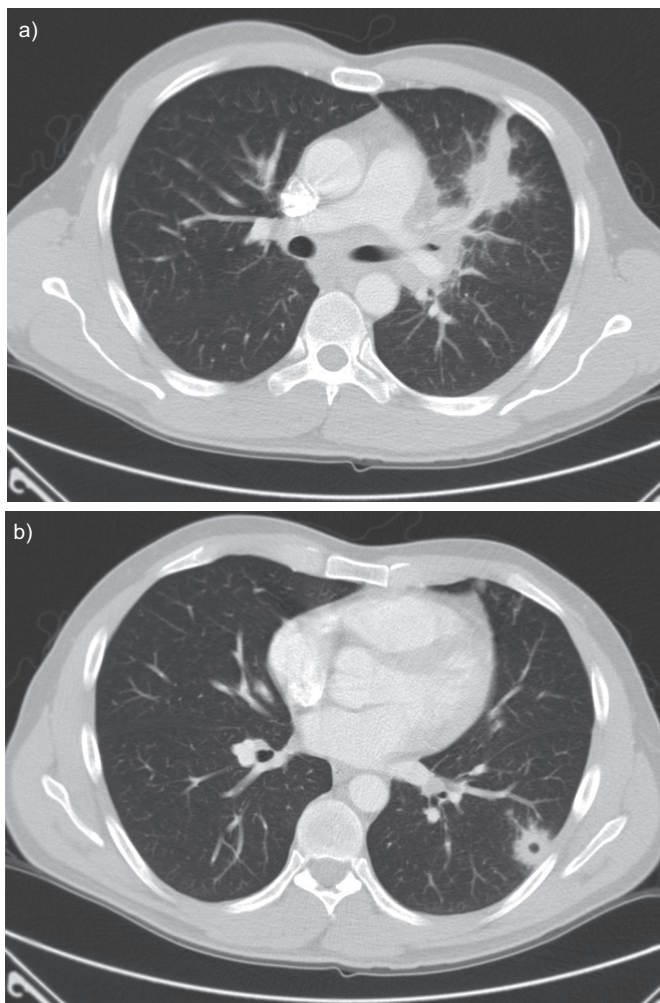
Chest computed tomography demonstrating a) lingular consolidation and b) a necrotising left lower lobe nodule.
